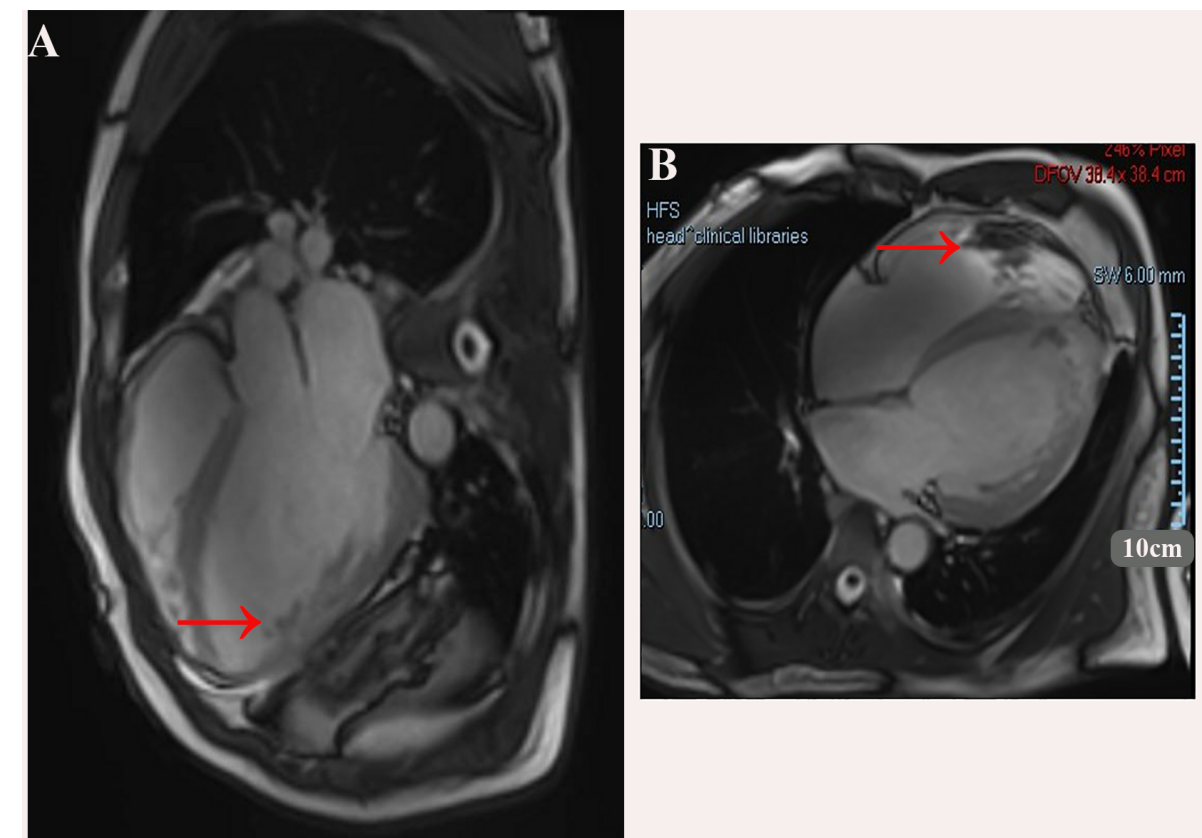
Showing the Cardiac magnetic resonance imaging, balanced steady-state free precession (bSSFP) cine sequence. (A) four-chamber view; (B) short-axis view. A large thrombus is seen adjacent to the apical/anterior wall of the left ventricle (red arrows). The left ventricle is markedly dilated.
